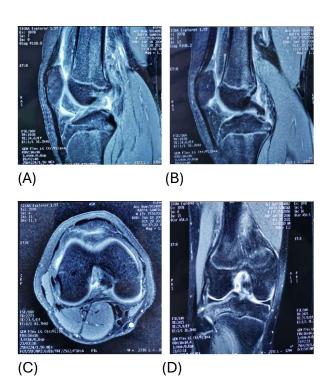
MRI of the right knee (A) Sagittal view of the right knee shows no ACL was seen (B) Sagittal view shows elongation of PCL (C) Axial view shows diminished ACL at femoral insertion (D) Coronal view shows no ACL was seen with hyperintense of the femoral insertion, while PCL was seen at the femoral insertion.
